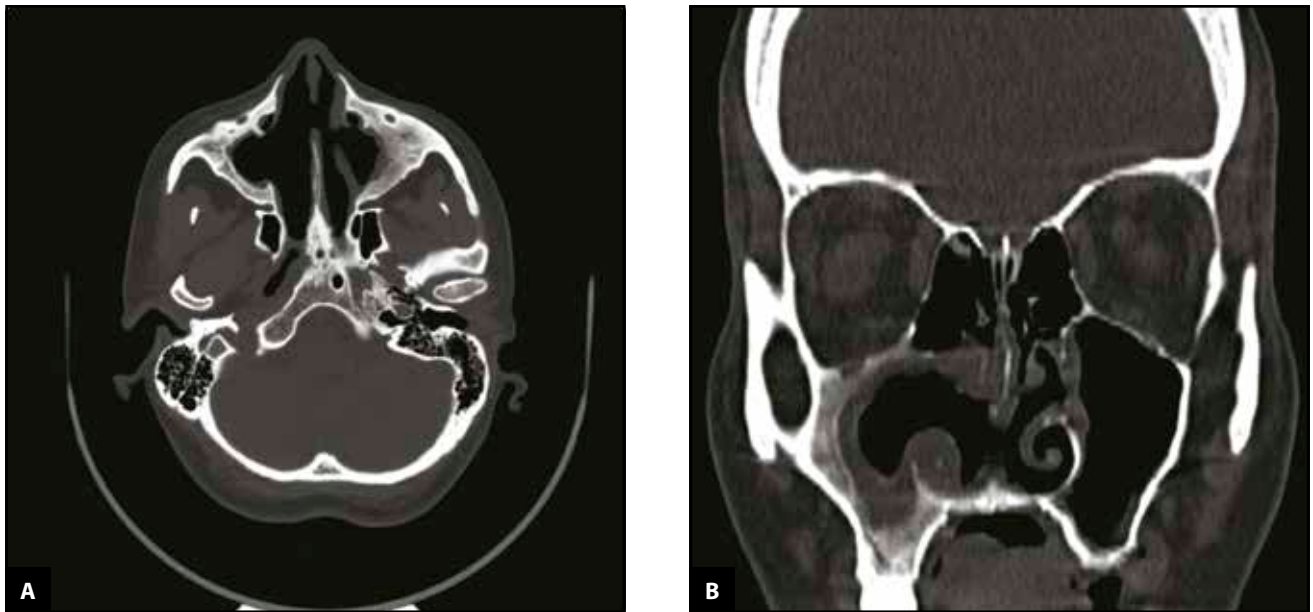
Postoperative follow-up CT scan of the nose and paranasal sinuses, axial and coronal slices, reveals bony erosions of the nasal septum, thickened and nodular mucosa.
